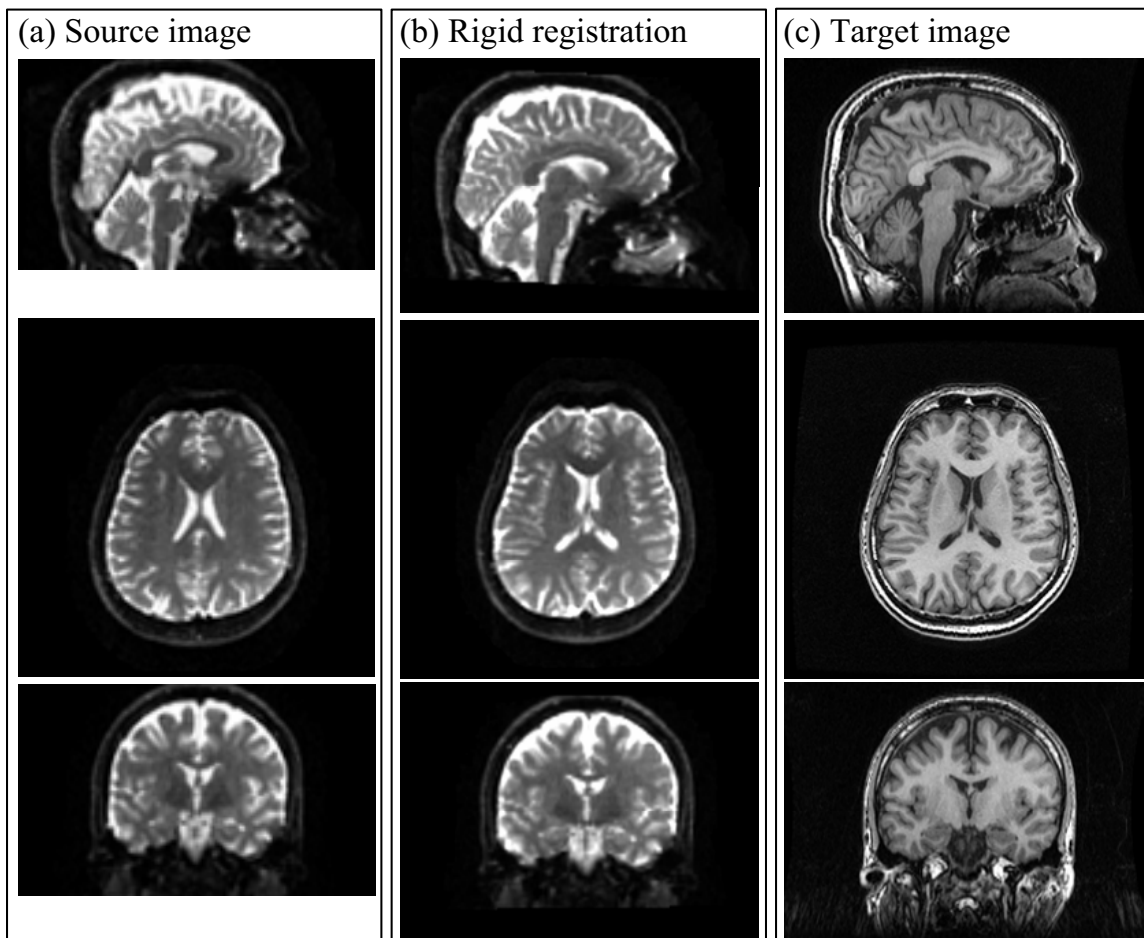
Intra-subject rigid alignment between non-diffusion-weighted and T1-weighted images using the proposed affine method. (a) Non-diffusion-weighted image as the source image. (b) Source image after the rigid registration. (c) T1-weighted brain image as the target image.
